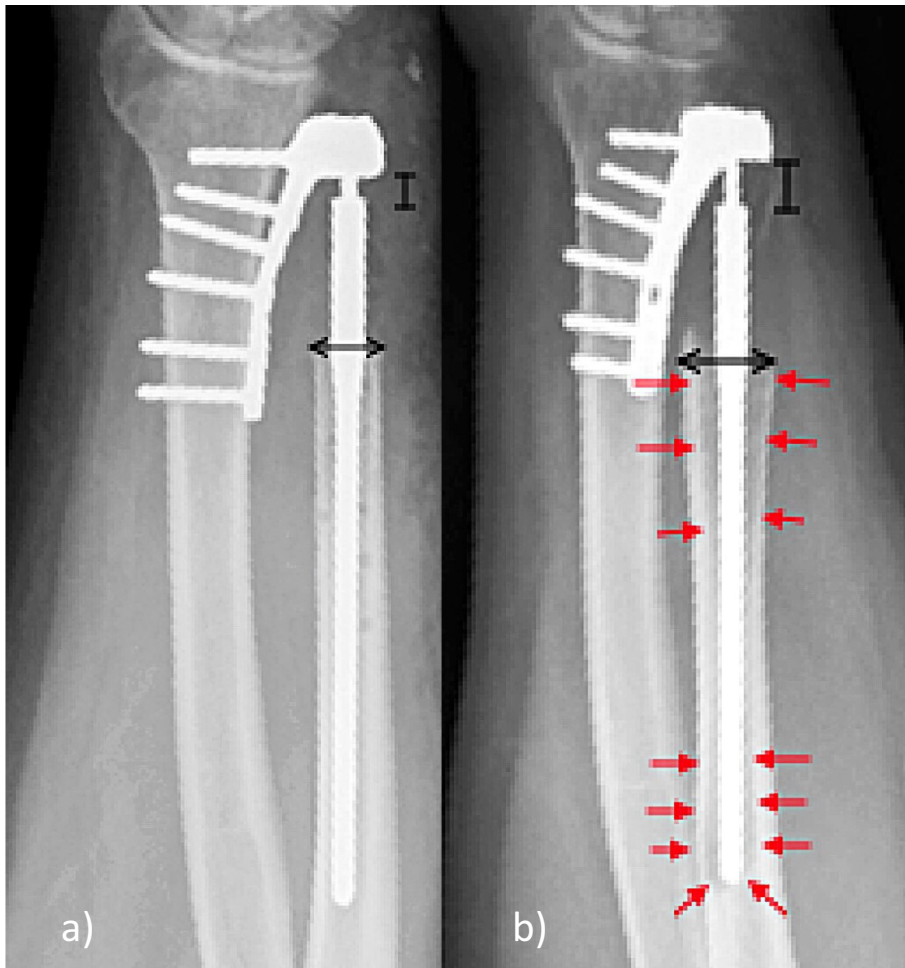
a: This image is the initial post-operative radiograph of the APTIS arthroplasty implantation, which reveals that the DRUJ appears stable. b: This image shows the loosening of the APTIS arthroplasty, as the ulna is ballooned and the stem is subsided. This image was taken 5 years after Fig. 4, the initial APTIS arthroplasty implantation.
